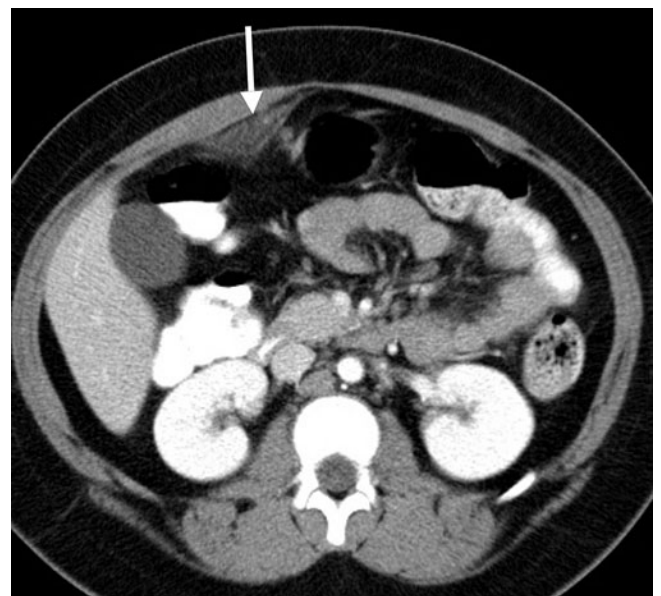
Omental infarction. Axial computed tomography (CT) shows a focal region of abnormal omental fat (*arrow*). This area was exquisitely tender to palpation
